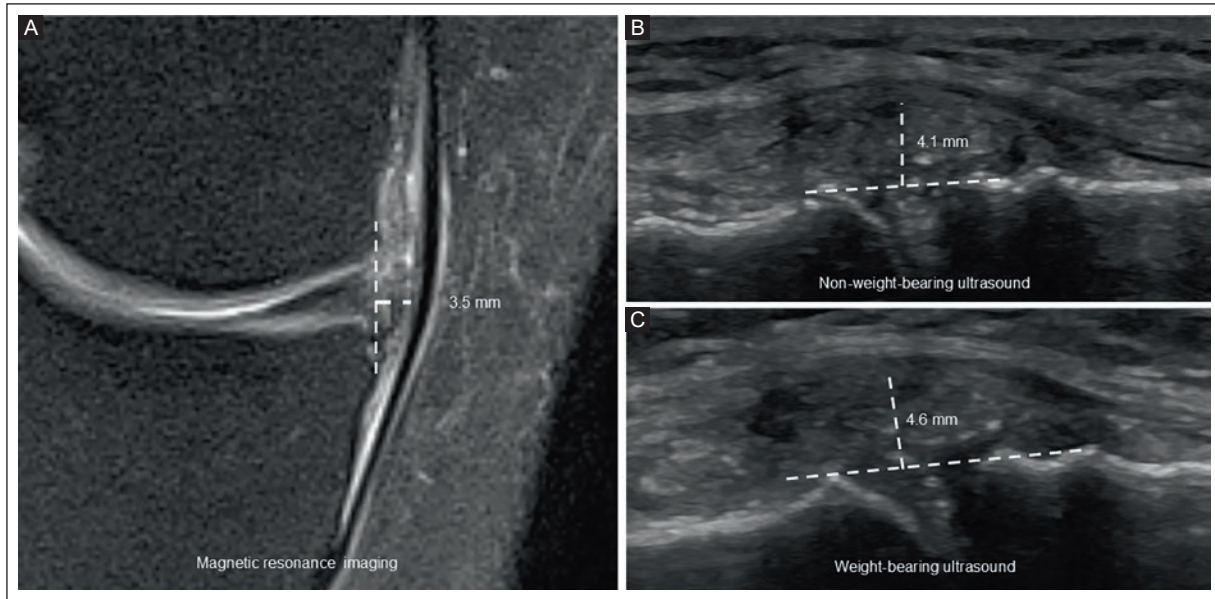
Comparison of imaging modalities for the medial meniscus of a 48-year-old obese man (BMI 31.2 kg/m²) with knee pain. A: coronal proton density-weighted MRI with fat suppression shows major 3.5 mm medial meniscal extrusion. B: NWB-US shows a major 4.1 mm medial meniscal extrusion. C: WB-US shows a major 4.6 mm medial meniscal extrusion.
